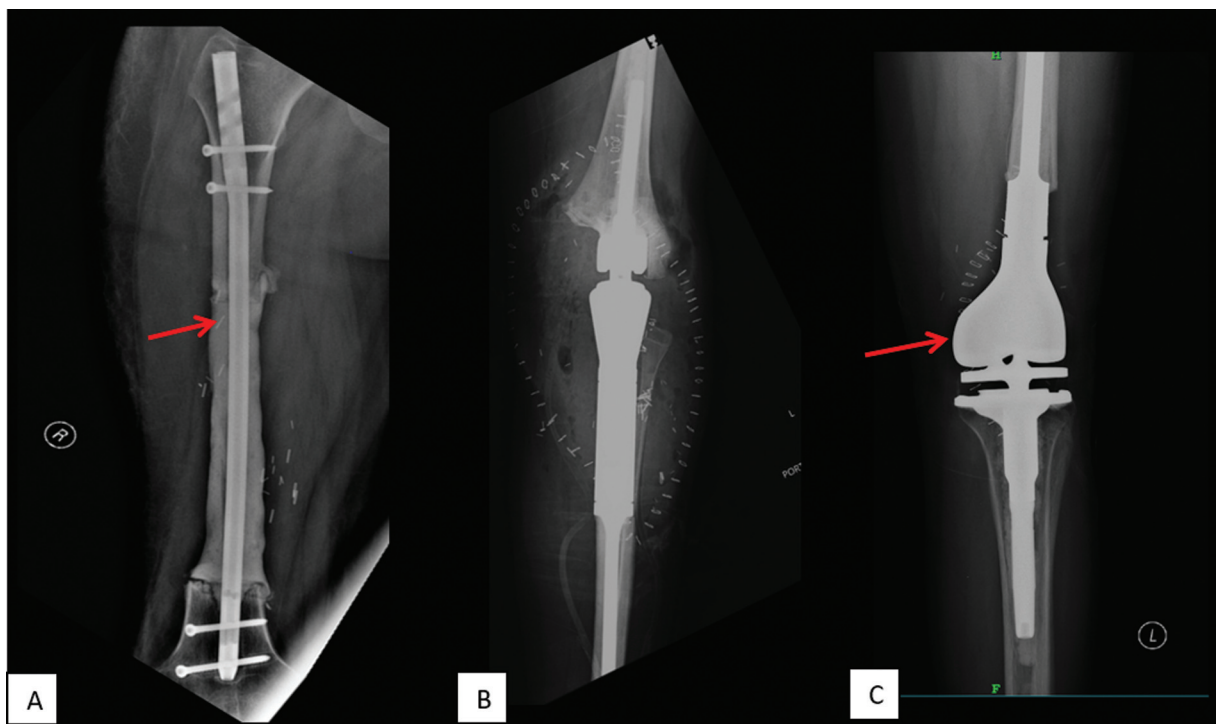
(A–C) Postoperative radiographs of all three patients showing the postoperative status after resection, with the reconstruction prosthesis in situ (*red arrows*).
